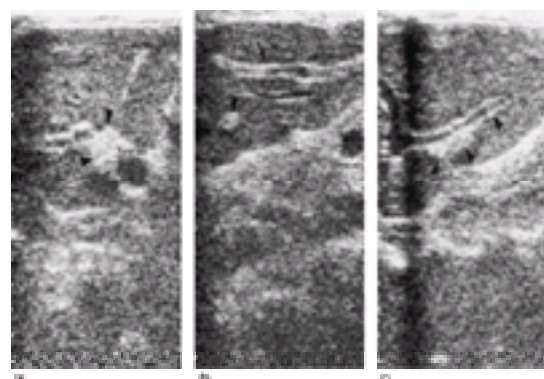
Ultrasonography of periportal fibrosis.
